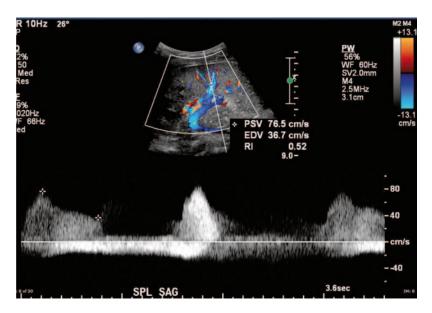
This Doppler study shows a large, hemodynamically important post-traumatic arteriovenous fistula that did not improve with time. It was eventually coiled by interventional radiology
